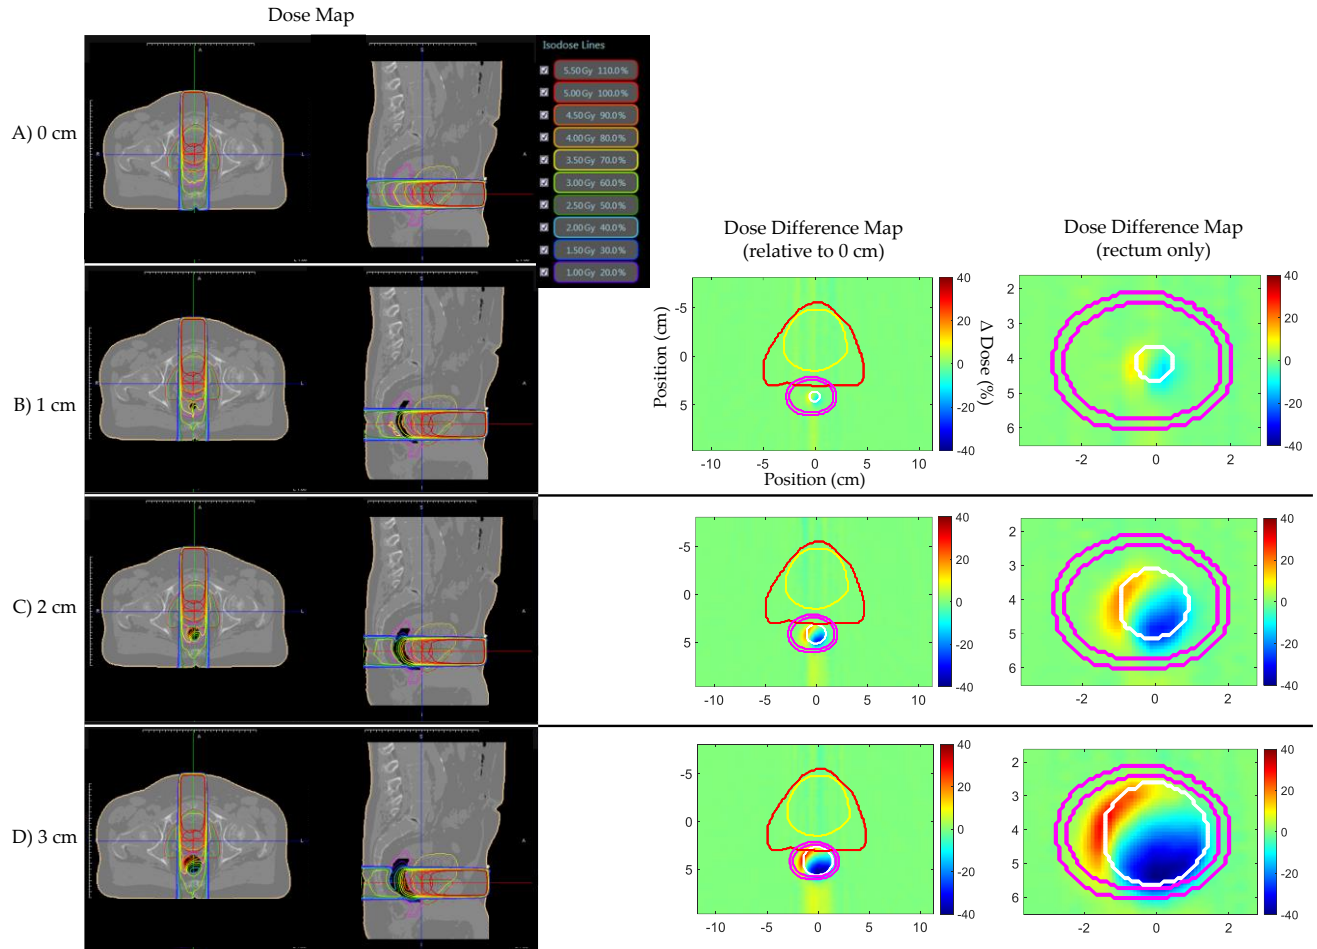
Prostate bed Patient A's AP plan dose distributions (overlaid on planning CT electron density map) and dose difference (Δ Dose (%)) maps for (A) 0, (B) 1, (C) 2, and (D) 3 cm artificial planning CT air cavity. Rectum dose difference maps show hot and cold spots within the rectum increased in magnitude and size with increasing air cavity size due to the electron return effect (ERE). Dose difference map planning CT contours displayed: Red—PTV; Yellow—bladder; Pink—rectum; White—artificial air cavity.
